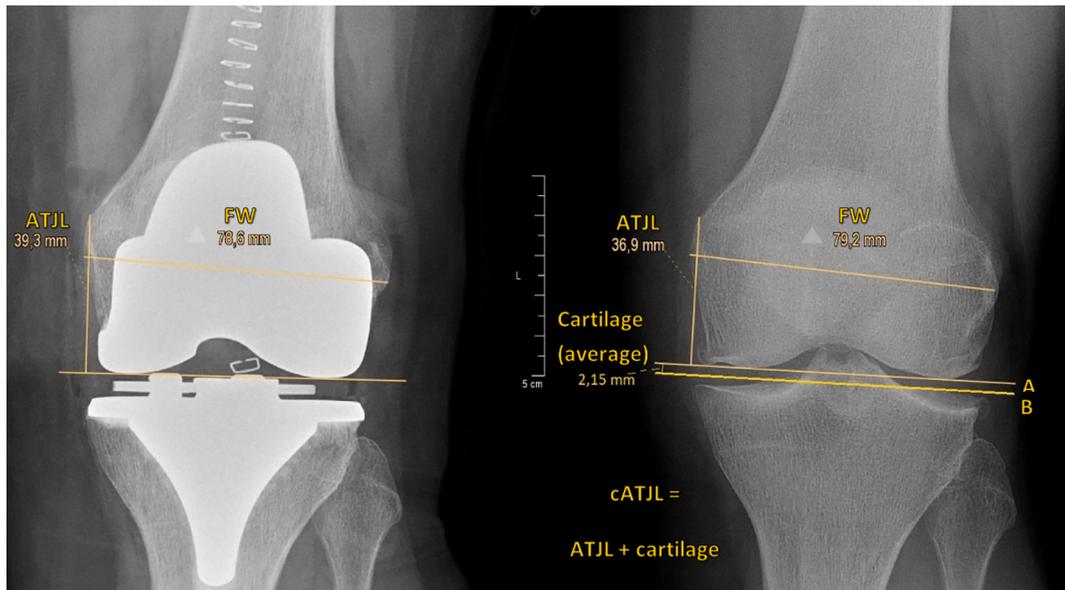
Radiological measurements for joint line changes pre- and postoperative. The right preoperative figure was taken eight years before surgery. At the time of surgery the patient had bone-to-bone osteoarthritis on the medial side. This radiograph was selected to elaborate more clearly the preoperative radiological measurement correction. Abbreviations: ATJL: Adductor tubercle joint line distance; FW: Femoral width; cATJL: corrected adductor tubercle joint line distance; A: joint line bony edge femur; B: actual joint position.
